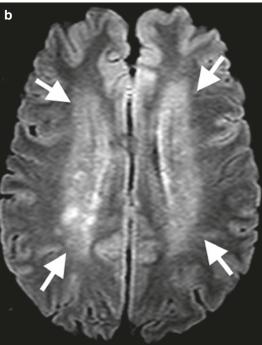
A 29-year-old female with SLE cerebral vasculitis (a) sagittal and (b) axial T2 FLAIR demonstrates periventricular and deep white matter high signal intensity
